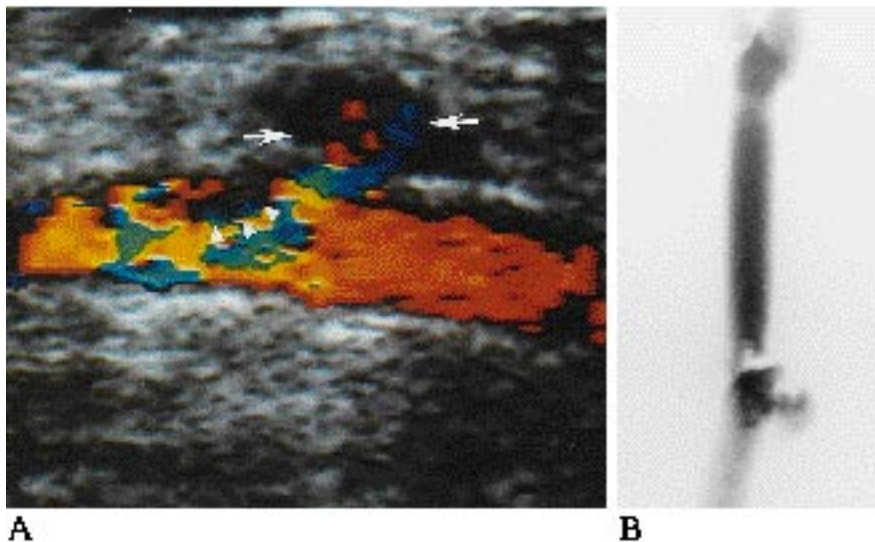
A, Longitudinal color Doppler sonogram of common carotid artery (CCA). Color flow within contained area in the soft tissues adjacent to the middle portion of the CCA is consistent with pseudoaneurysm (between *arrows*). Just distal to the pseudoaneurysm is a linear density that does not fill with color, interpreted as an intimal flap (*arrowheads*).
